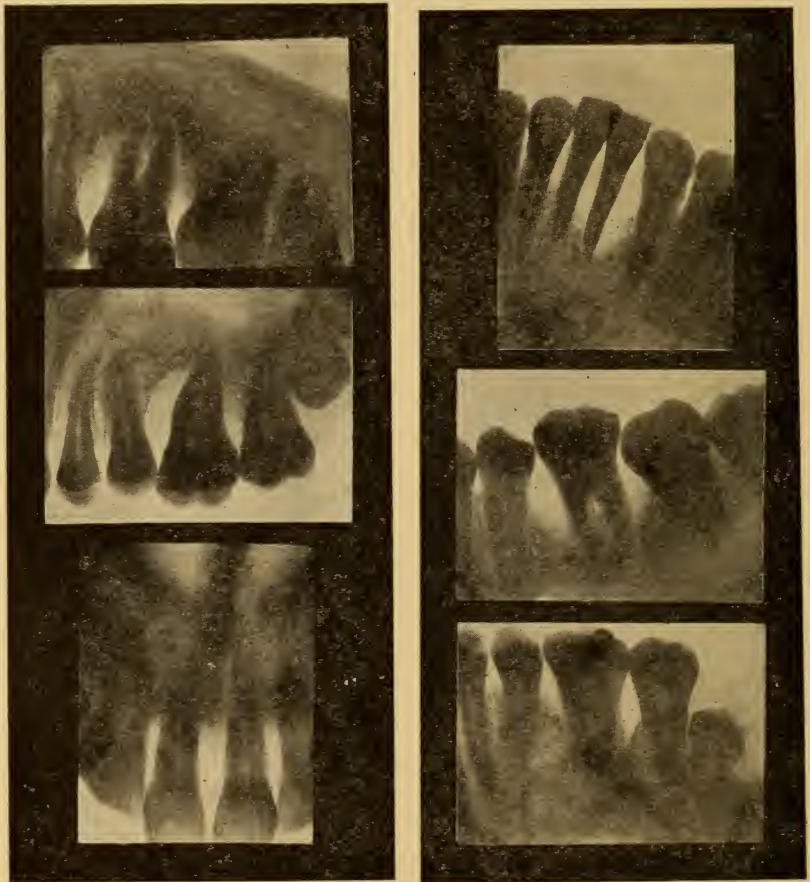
RADIOGRAPHS OF DR. MERRITT'S CASE.
